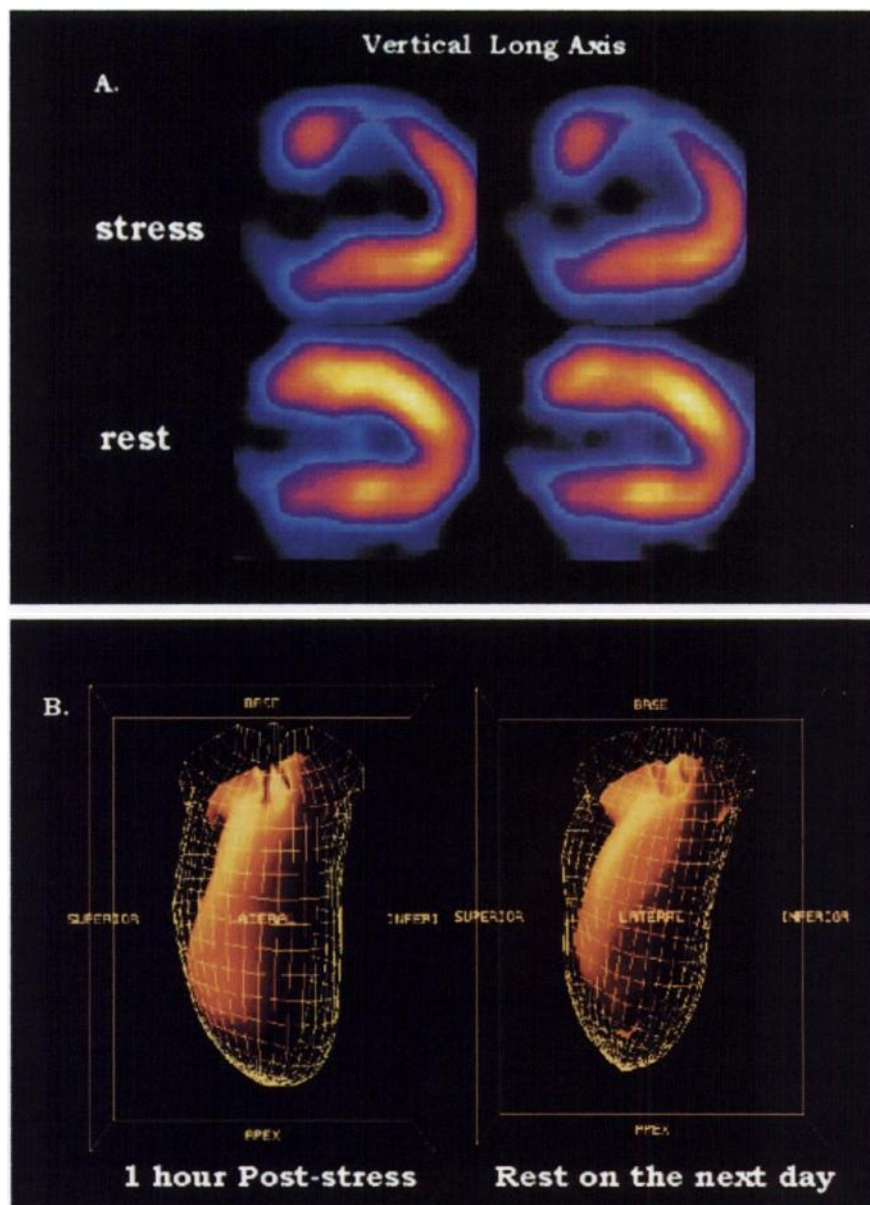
^{99m}Tc -MIBI SPECT in 64-y-old man. (A) Reversible perfusion defect in mid anterior wall. (B) Akinetic wall motion abnormality in perfusion-defective area during 1-h poststress period improved much during resting period.
